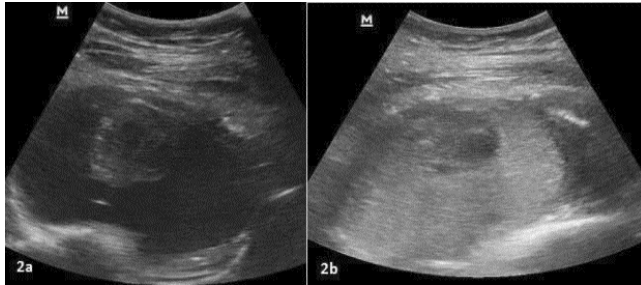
a) Ultrasound shows 22 G spinal needle within the pseudoaneurysm. b) Ultrasound shows near complete thrombosis of the pseudoaneurysm.
